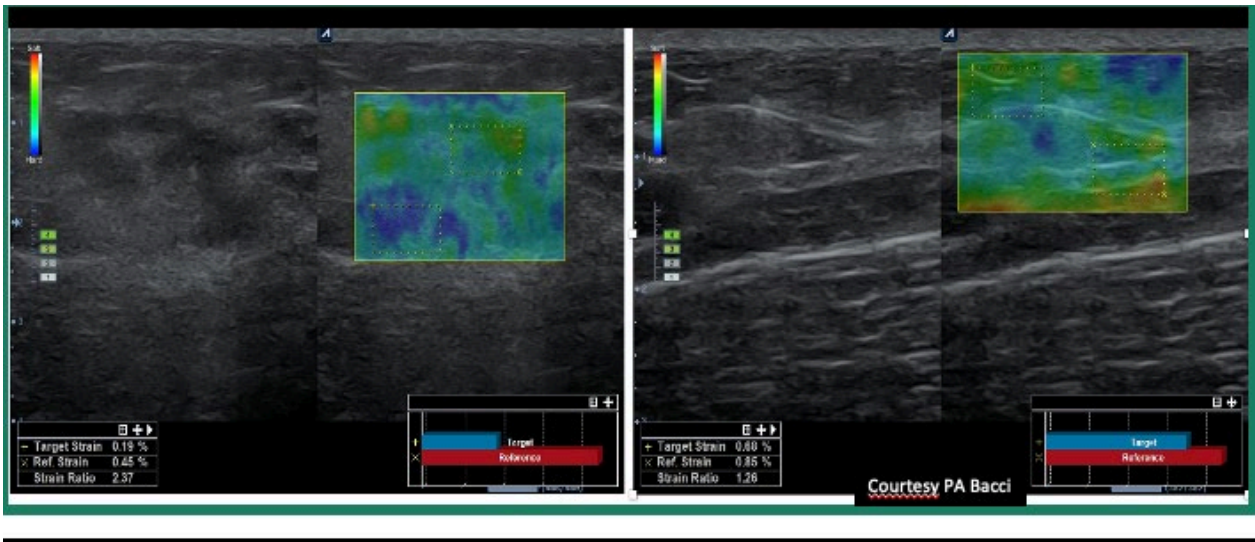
Post-treatment color Doppler elastosonography of the left gluteus showing improvement, with no fibrotic evolution of nodules and preservation of the implant.
